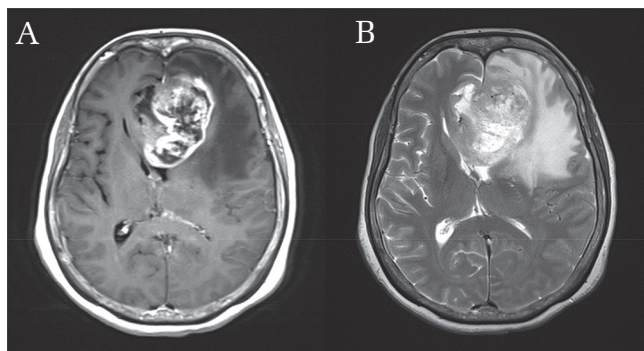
Magnetic resonance imaging findings of GBM reflect their pathologically heterogeneous features. On gadolinium-enhanced T_1 -weighted images (A), remarkable enhancement is seen in the main mass, a result of extravasation of contrast media through BBB-disrupted neovasculature. Large necrotic areas occupy the tumor center, while viable tumor cells and abnormal vessels tend to accumulate in the periphery. On T_2 -weighted MR images (B), a broader area of high intensity reflects increased water mobility in areas of both edema and invasive tumor.
